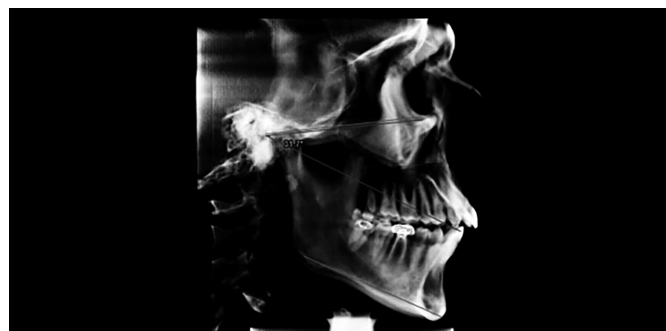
Lateral Cephalogram reconstructed from CBCT.
